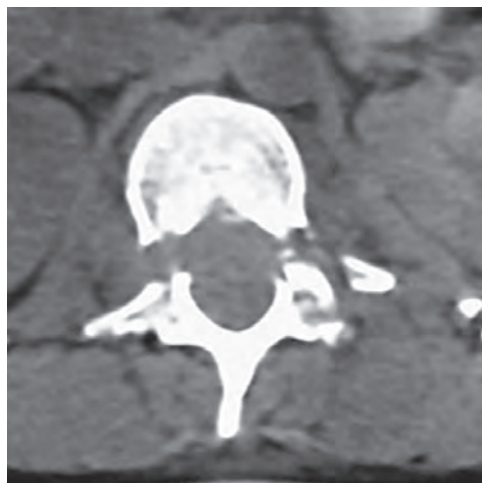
CT showing fracture of both pedicles due to bullet injury
